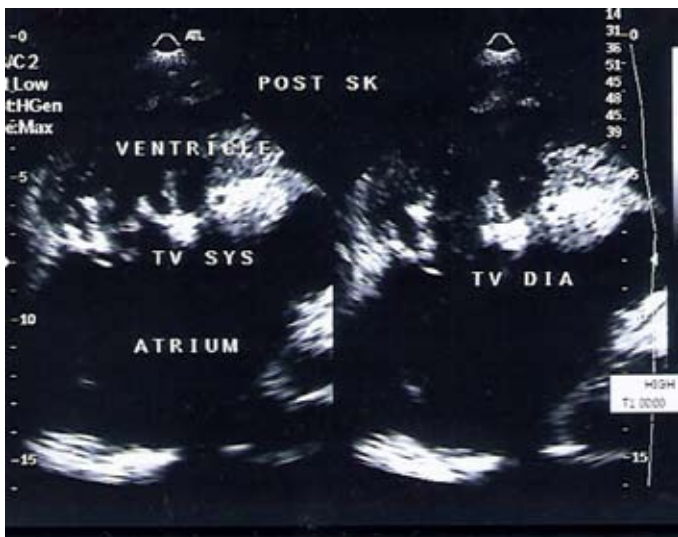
Repeat Transthoracic Echocardiogram done 24 hours after intusions.
